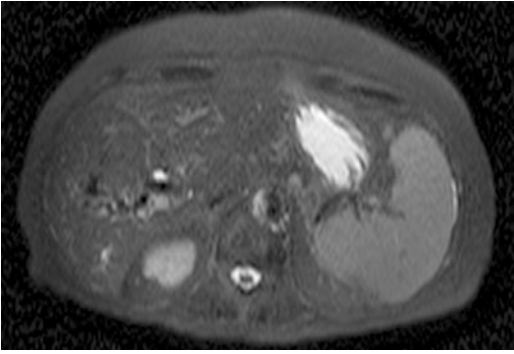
Portal vein thrombosis. Axial T2-w fat-saturated HASTE image depicts right portal vein thrombosis with signs of periportal cavernomatosis. Because the patient had contraindications to contrast-medium administration (allergy and nephropathy), diagnosis of thrombosis of portal vein was confirmed by means of ultrasonography
